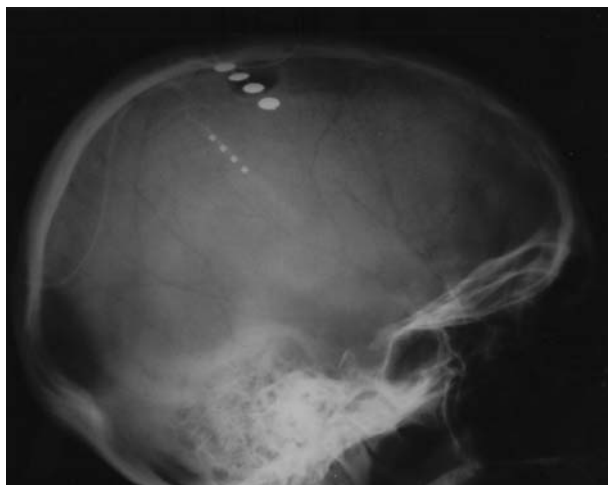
Radiograph showing the MCS apparatus in place
